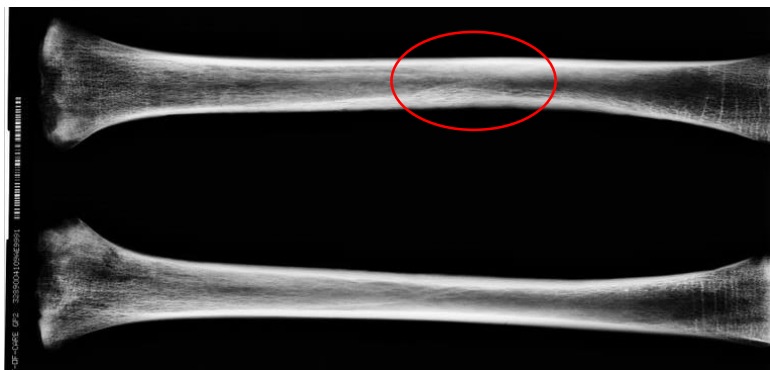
Radiograph of tibial fracture. Posterior view of left (top) and right (bottom) tibia. Healed fracture at the mid-shaft in the left tibia with increased cortical thickness. Note a general decrease in cortical thickness in the left tibia compared to the right. From Dunstable, skeleton AI. (with permission from Luton Culture)
